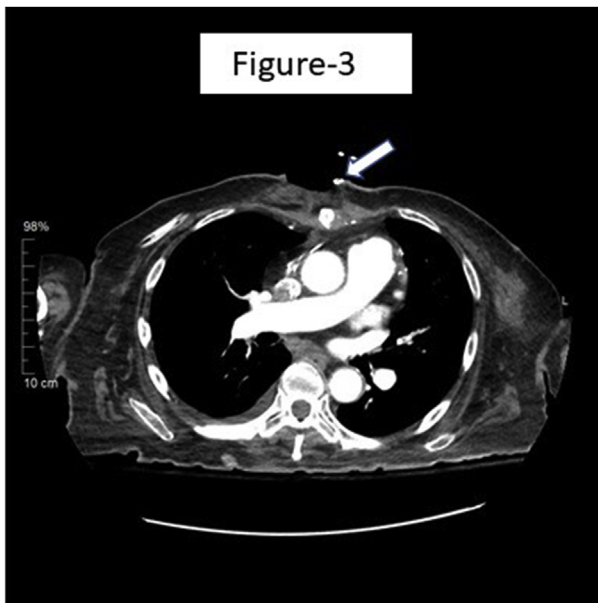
(Day-512), Contrast CT of the chest depicts the post-operative status after sternectomy and resolution of infection followed by plastic reconstruction.
